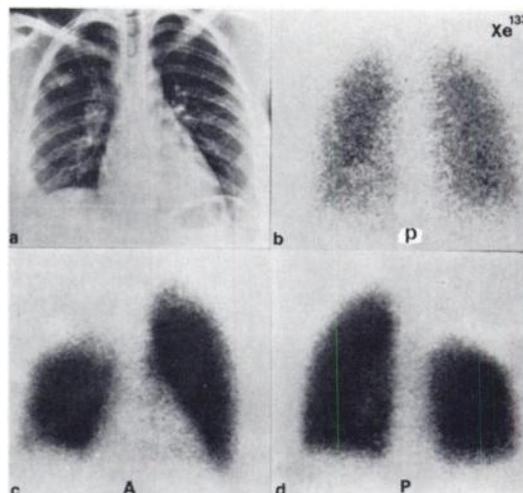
Case 3. (a) Chest radiograph showing infiltrate in right upper lobe. (b) Posterior Xe-133 scan showing uniform distribution of air to both lungs. No evidence of air trapping was seen in washout images. (c, d) Tc-MAA scans show unmatched perfusion defect.
